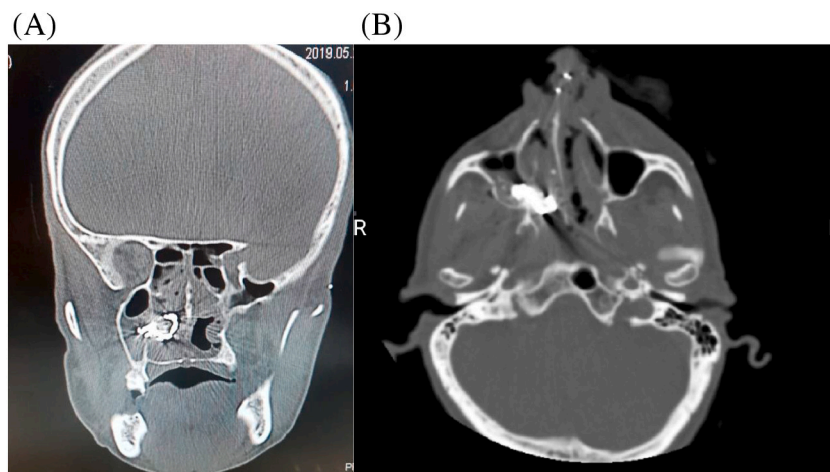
CT scans show the bullet shrapnel in medial wall of maxillary sinus near the sphenopalatine artery, as well as damage to anterior maxillary sinus plate and right lacrimal bone. (A) Coronal view, (B) Axial view.
